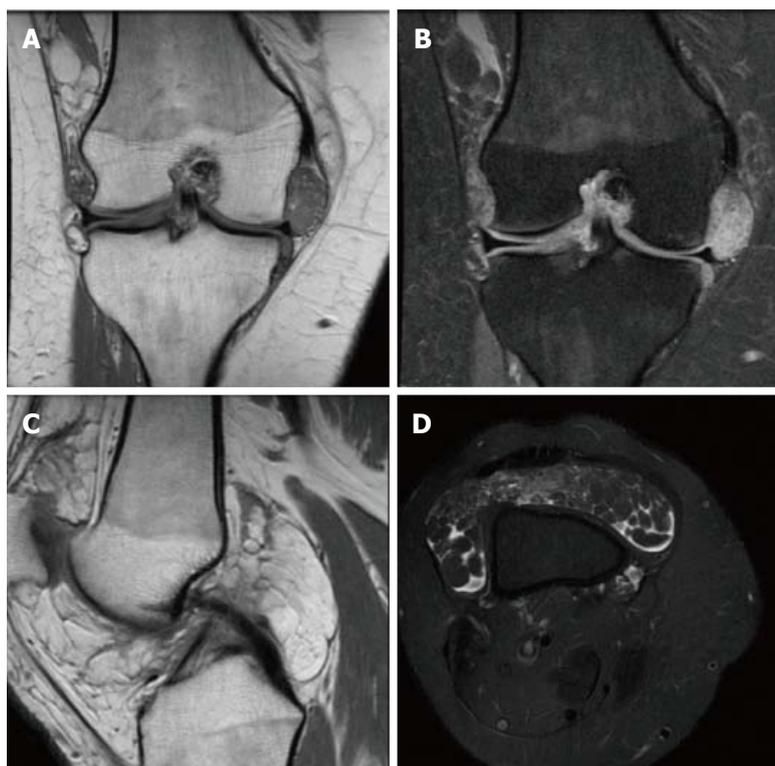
Right knee magnetic resonance imaging demonstrating effusion in the suprapatellar bursa and hypertrophic synovium with leaf-like projections of tissue which has the same signal intensity as fat. A: Coronal proton density (PD); B: Coronal PD fat saturation; C: Sagittal PD; D: Axial T2 fat saturation.
